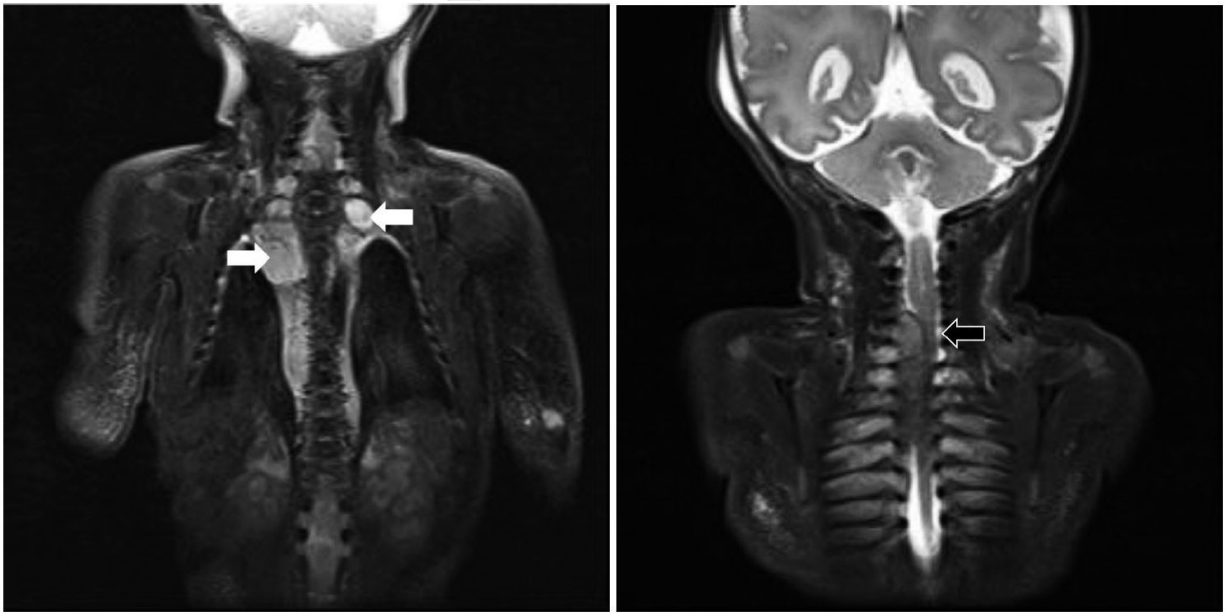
Image of MRI reveals multiple neurofibromas along bilateral paravertebral regions of neck and mediastinum, and in epigastric region (white arrows). The mass effect of the mentioned lesions with some intraspinal extension on the right side, leading to compression of spinal cord (black arrow).
